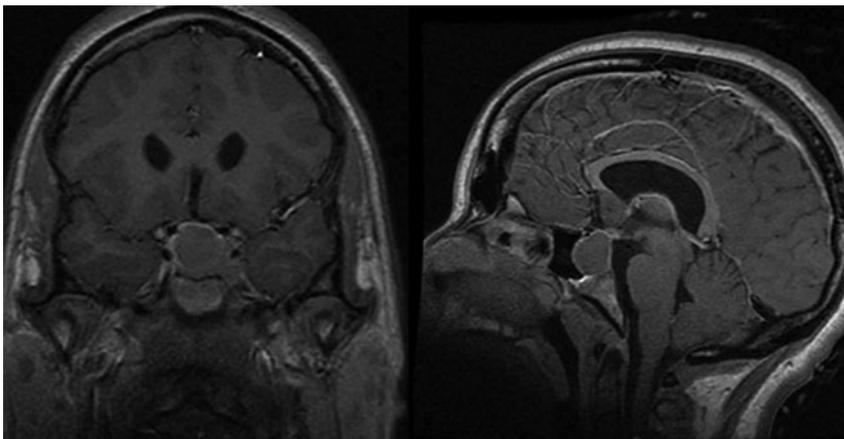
Somatotropinoma. Coronal and sagittal T1-weighted gadolinium-enhanced images revealing a right-sided intrasellar adenoma. Note the frontal bossing and expanded diploic space on the sagittal image.
